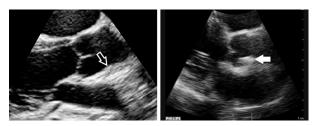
Parasternal long-axis view on a transthoracic echocardiogram showing normal appearing aortic root and sinotubular junction (open arrow) and calcification of the sinotubular junction (solid arrow).
